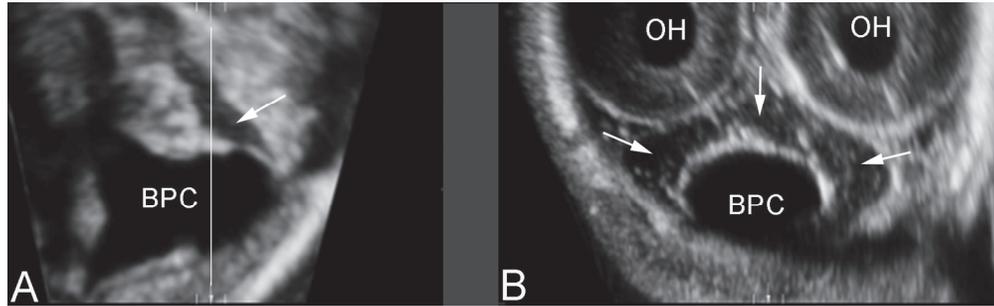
Three-dimensional ultrasound with multiplanar and volume contrast imaging. Using a high frequency (6-12MHz) transvaginal transducer, the fluid content of the Blake's pouch (BPC) appears completely sonolucent, whereas the content of the cisterna magna (arrows) shows some grainy textures with thin vertical strands. A) midsagittal view; B) coronal view. (OH: occipital horns of the lateral ventricles)
